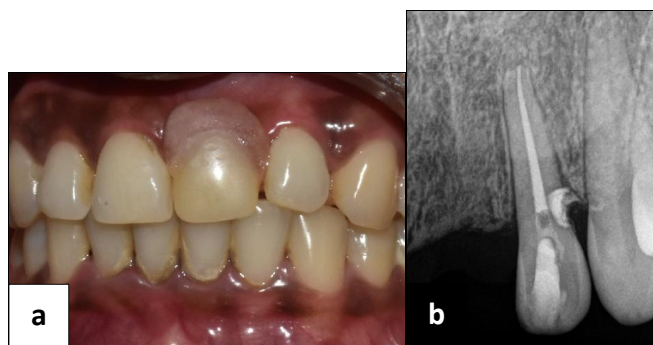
a) Follow-up photograph after 1 year; b) Follow-up radiograph after 1 year
